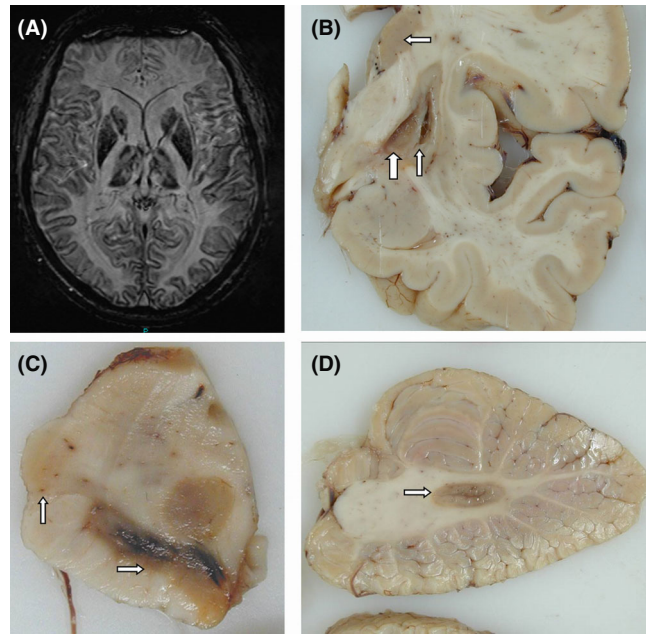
Macroscopic pathology in HF. (A) MRI image of an individual with HF in an advanced stage with cavitation of the basal ganglia and decreased signal intensity in thalamus and lower layers of the cerebral cortex. Coronal sections of fixed brain tissue: (B) In case III, there are cystic cavities in the globus pallidus (broad vertical arrow) and within the putamen (narrow vertical arrow), with sparing of the caudate nucleus (horizontal arrow). The cerebral cortex shows discoloration in the lower layers at the border with white matter. (C) Midbrain from Case III showing normal melanization, but with diffuse brown discoloration of the substantia nigra pars compacta and pars reticulata, along with cerebral peduncles (horizontal arrow). There is some discoloration of the medial geniculate body (vertical arrow). (D) Cerebellum from Case III showing the dentate nucleus with brown discoloration and possible cavitation (arrow). The cerebellar cortex appears normal.
